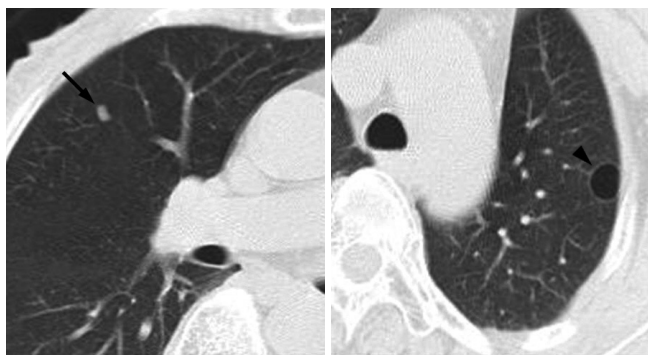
Chest CT scans with mediastinal window setting.
